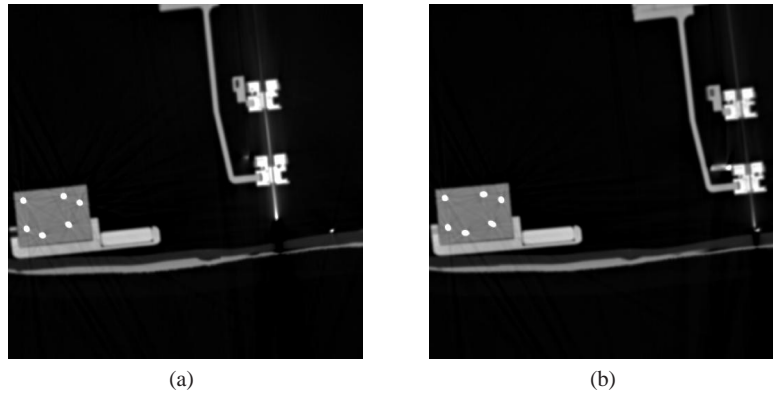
"Look and move" with CT scanners. (a) The needle is maintained in the needle-holder jaws of a lightweight parallel robotic platform (CT-Bot), which has to be moved to the target point (right). (b) A new acquisition to check for the final positioning.
